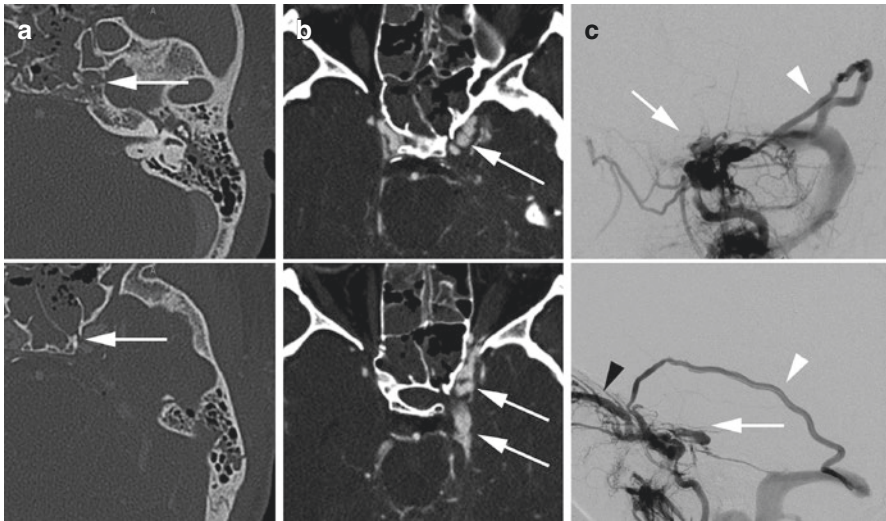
Direct cavernous carotid fistula. Patient following a motor vehicle crash with skull base fractures and left cavernous carotid fistula. CT bone algorithm (a, top and bottom) demonstrates extensive skull base fractures through the sphenoid sinus and carotid canal (arrows). CTA (b, top and bottom) showed asymmetrically enlarged and irregular left cavernous sinus with arterial phase enhancement (arrows). DSA (c, top = frontal projection and bottom = lateral projection) confirmed a posttraumatic direct cavernous carotid fistula (arrow) with cervical ICA injection. Immediate venous contrast enhancement was present in the vein of Labbe (white arrowhead) extending into the sigmoid sinus as well as the superior ophthalmic vein (black arrowhead)
